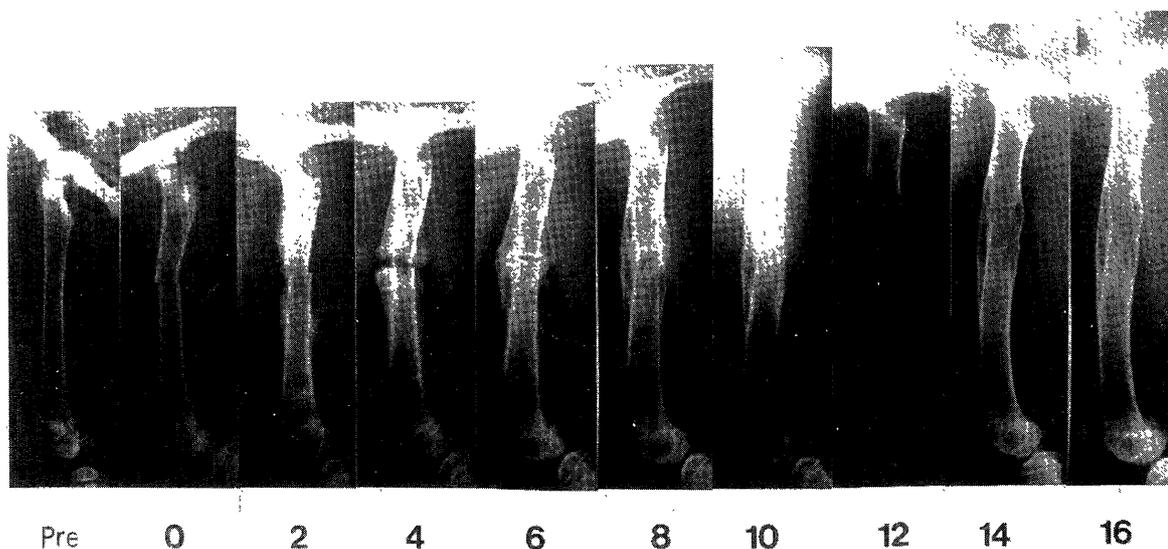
Radiographic changes in the treated femur in the lateral projection.
